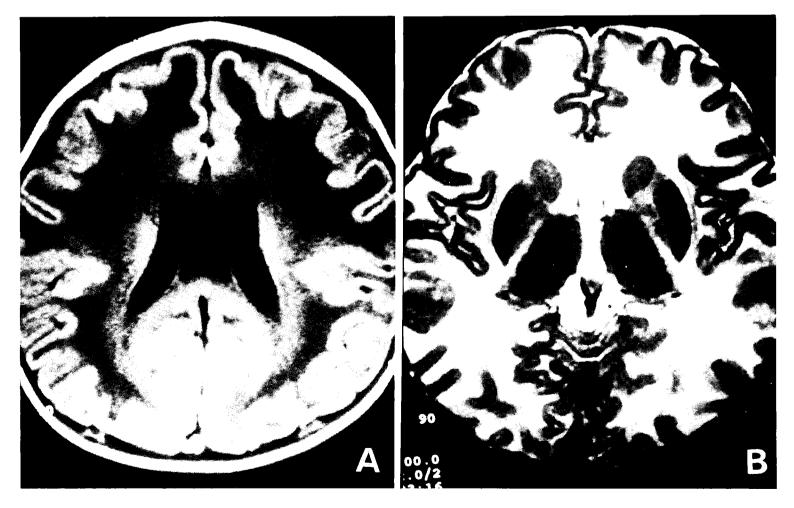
Brain MRI(A) T1-weighted axial image. (B) T2-wighted axial image. MRI shows extensive white matter demyelination with gyral extension.
